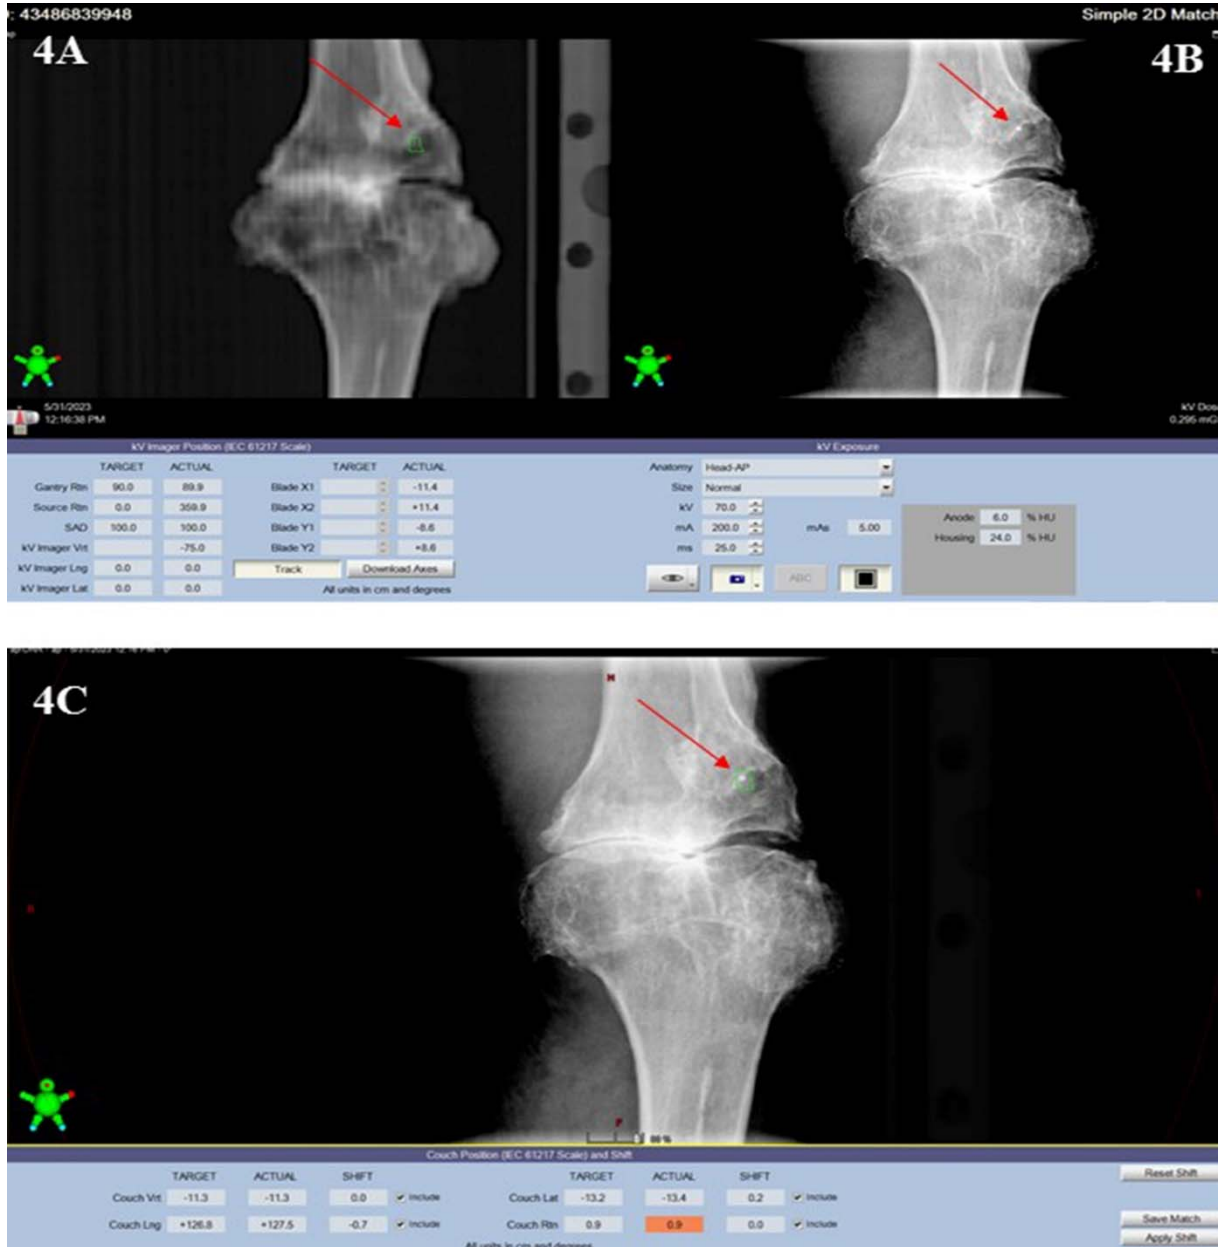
Treatment application, radio-opaque marker appearance providing ease of radiotherapy set up. The radiopaque marker appears as marked (red arrow) on the Digitally Reconstructed Radiograph (DRR) from the treatment planning system (A). The marker (red arrow) on the patient's skin is visible on the KV port taken during set-up before the treatment starts (B). Image (C) where both markers overlap (red arrow) by matching both images.
